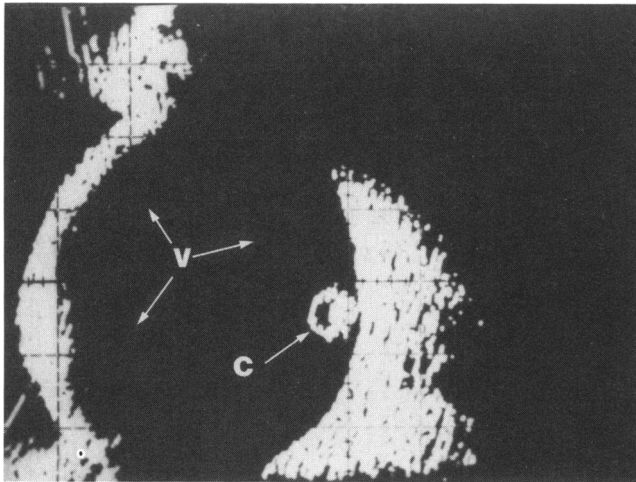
Upper: B scan ultrasonography of the patient's left eye (horizontal cut). Note the intravitreal echoes just anterior to the optic nerve shadow (N) corresponding to the intravitreal cysticercus (C). The cysticercus is on the anterior surface of the optic nervehead. The retrobulbar fat pattern and optic nerve (N) shadow are acoustically within normal limits.
